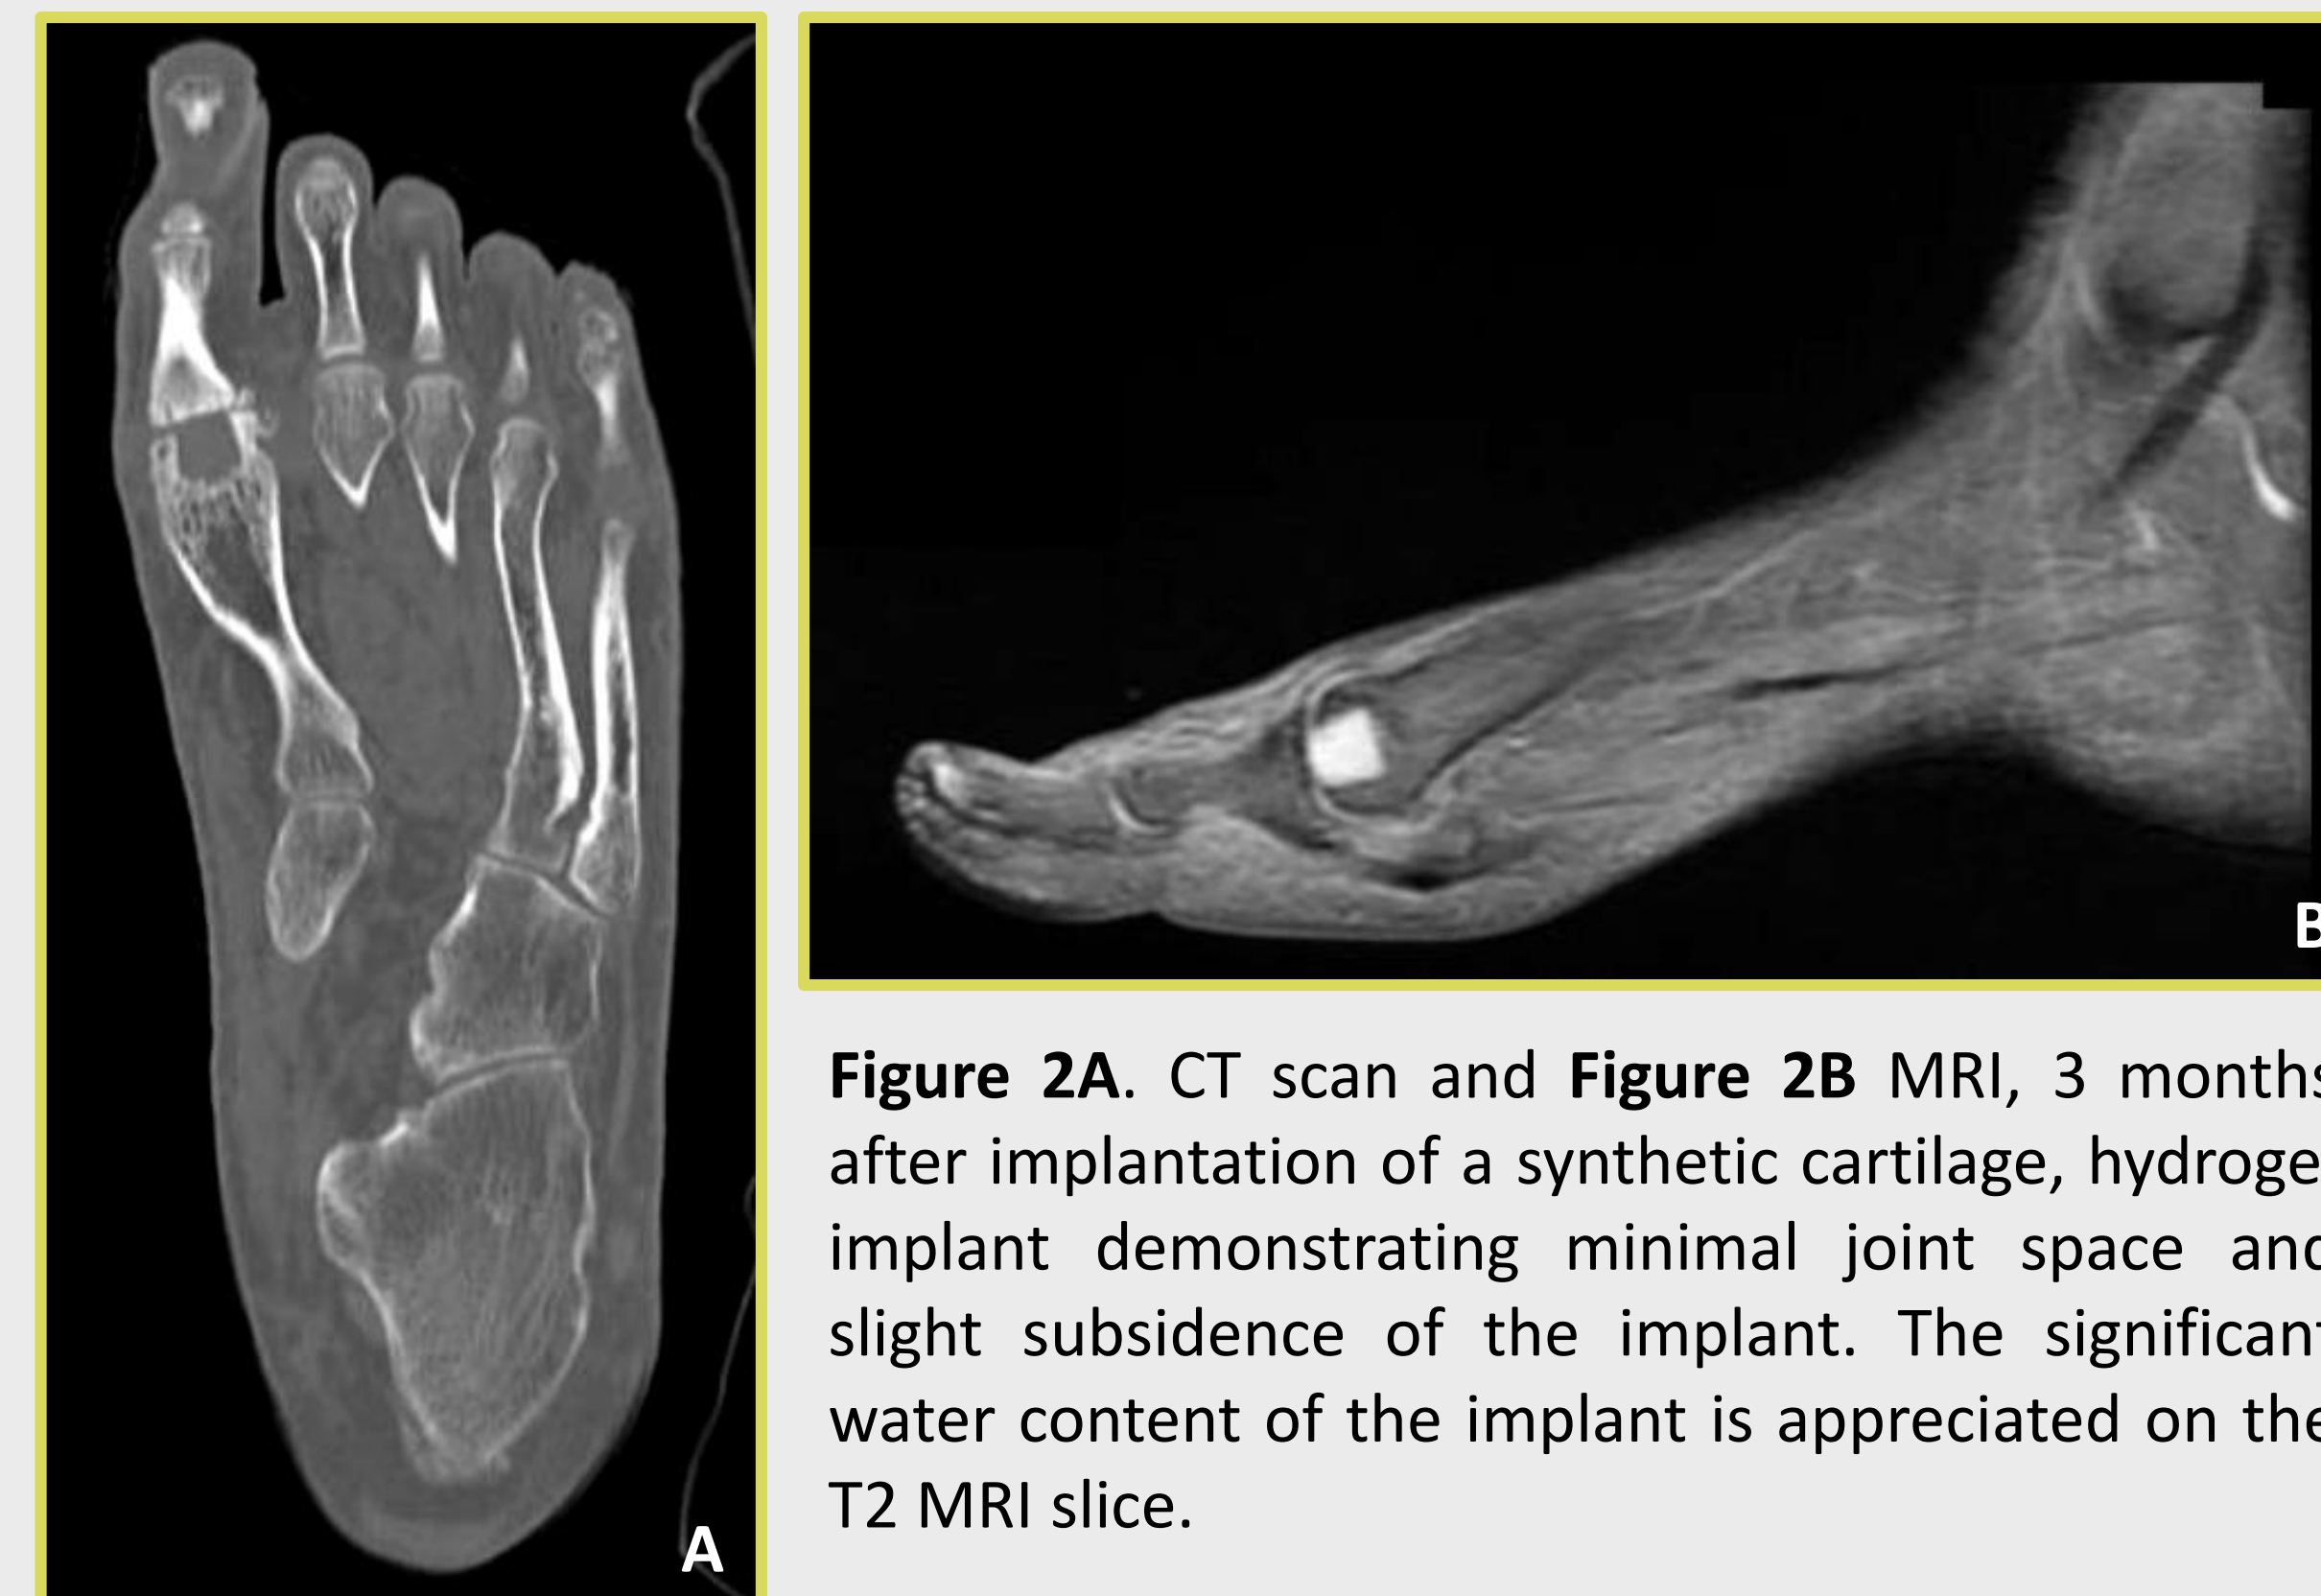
CT scan and Figure 2B MRI, 3 months after implantation of a synthetic cartilage, hydrogel implant demonstrating minimal joint space and slight subsidence of the implant. The significant water content of the implant is appreciated on the T2 MRI slice.
